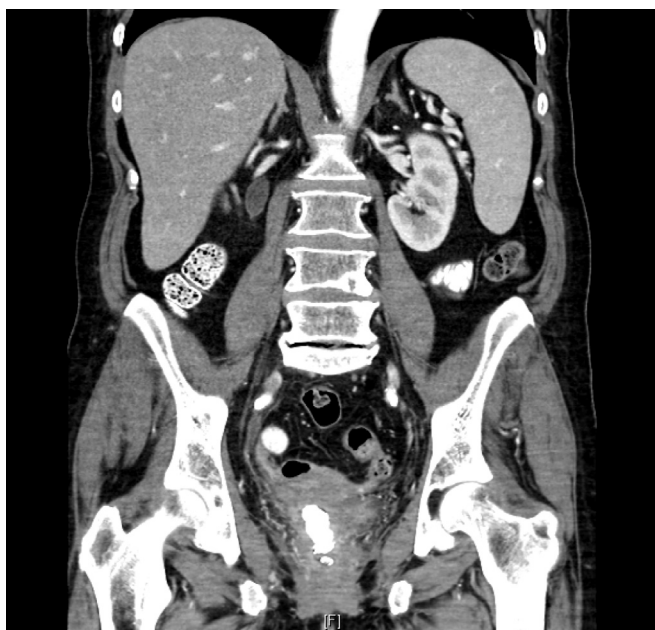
CT, coronal section, showing linear radiopaque material in the vaginal canal with a smaller distal extension.
